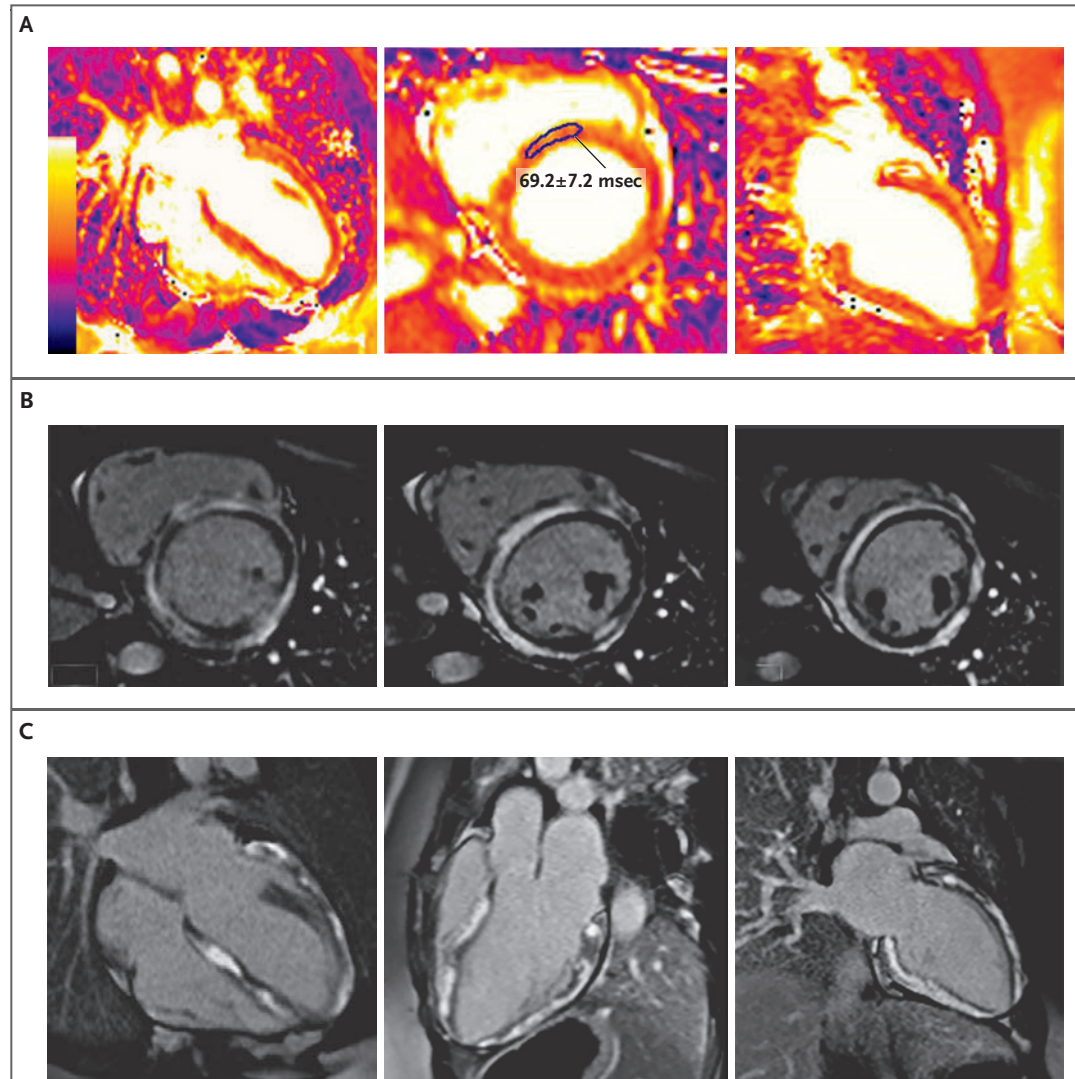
Cardiovascular MRI.
